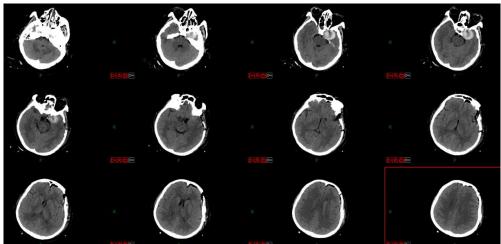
Postoperative day 1 CT scan showing no new hypodensities or hyperdensities.
